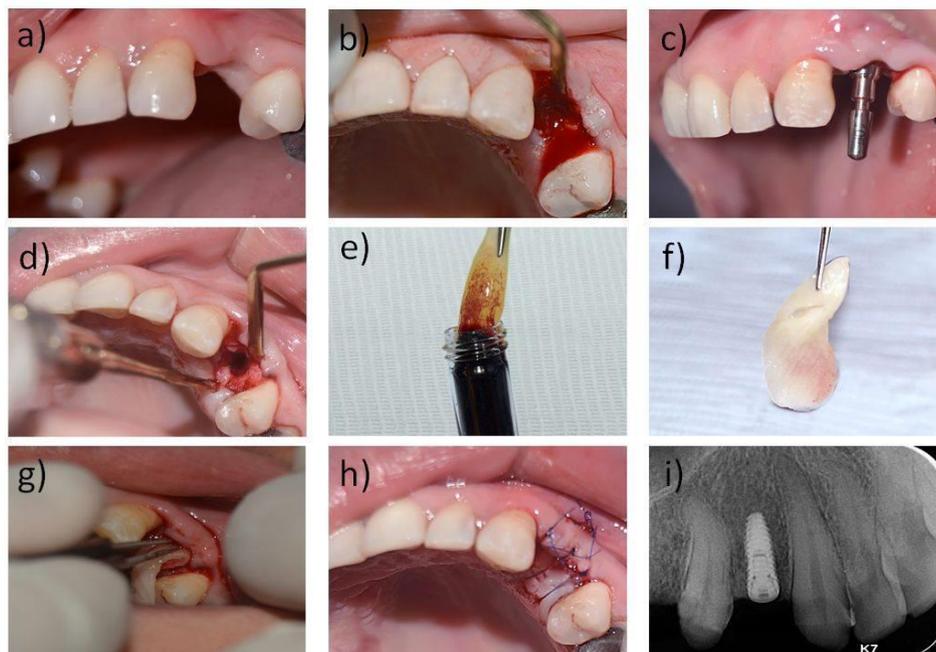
Implant placement and soft tissue augmentation with a PRF membrane. a) Missed first premolar with thin buccal gingival phenotype, b) Full mucoperiosteal flap reflection, c) Implant positioning verification using the guiding pin, d) The completion of osteotomy site preparation, e) PRF prepared from the patient's own blood sample, f) PRF membrane obtained by squeezing the PRF between two pieces of gauze, g) Implant placement and soft tissue augmentation, h) Surgical site suturing using a non absorbable 5/0 polypropylene suture, i) Periapical radiograph taken immediately after implant placement.
